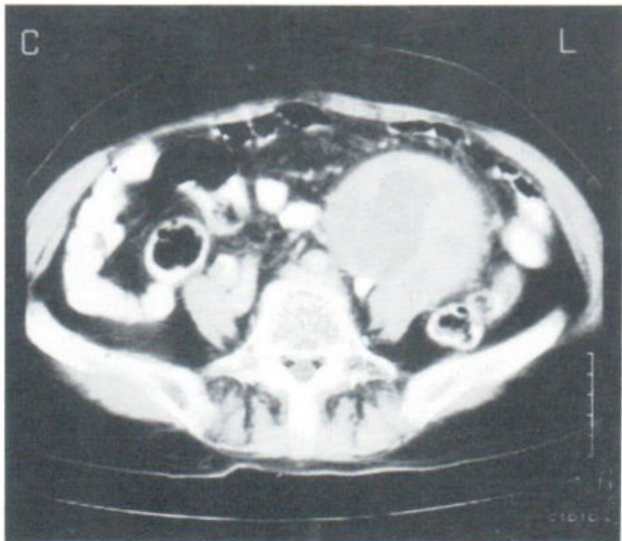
Contrast enhanced CT scan. Intense enhancement in solid part is noted.
